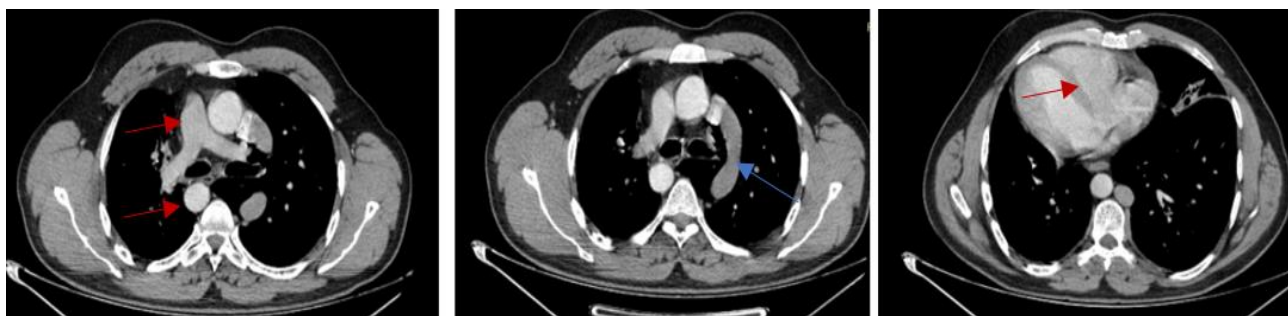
b: Thoracic CT axial section in mediastinal window with injection of non-ionic iodinated contrast: dextrocardia with thoracic aorta on the right of the vertebra, the trunk of the pulmonary artery on the right associated with a left hemi azygos vein following the path of a left upper lobar supernumerary scissure
